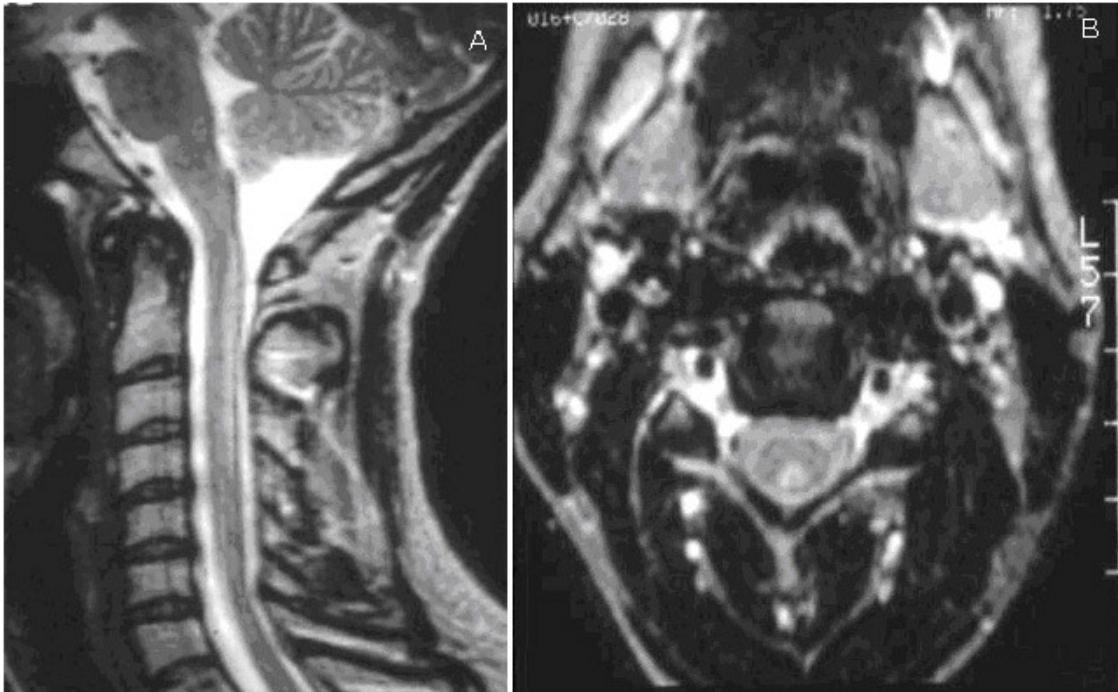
A young woman developed symptoms of paraesthesia in both legs. First MRI performed in 2003 was diagnosed as spinal tumor, and she was scheduled for operation, but a second MRI showed regression of the lesion. A year later the lesion was smaller, and at the end of 2005 it had completely disappeared. Patient has had no new lesions or clinical symptoms since.
